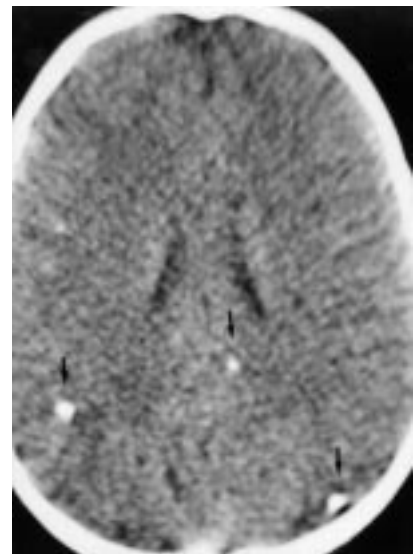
Intracerebral calcifications (arrows) suggestive of congenital toxoplasmosis found on the computed tomogram.
